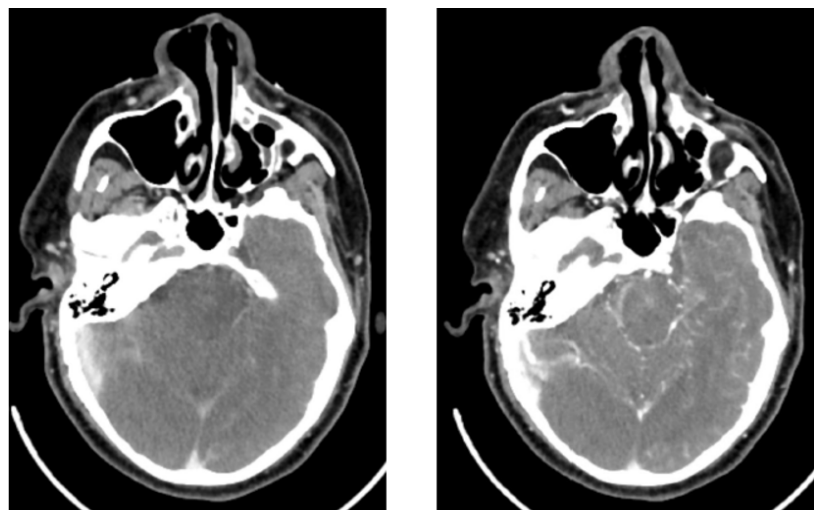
Computed tomography angiography of the brain and neck, suggestive of complete occlusion of the right internal carotid artery (ICA), dissection flap in the proximal ICA with absent flow in the right middle cerebral artery territory.
